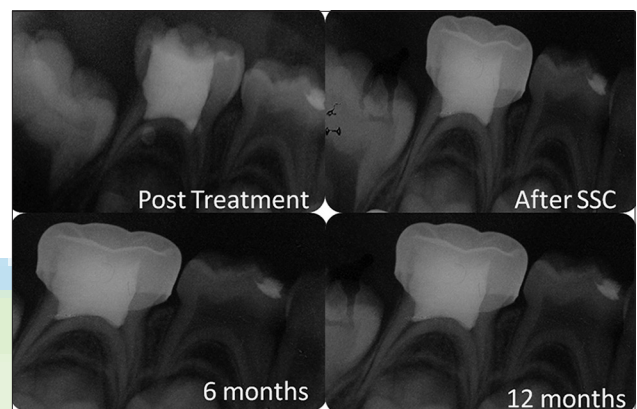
Follow-up radiographs after Diode laser and Zinc oxide eugenol pulpotomy
